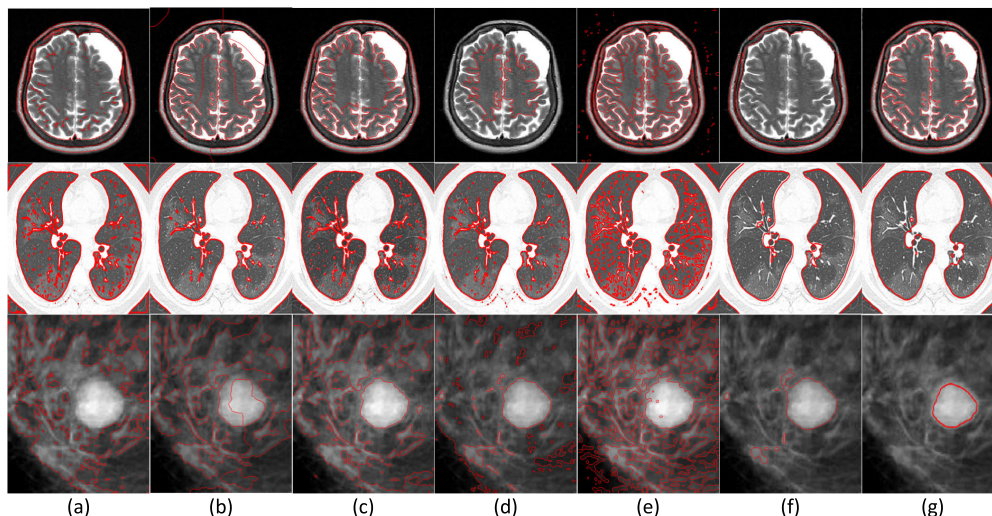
Segmentation and corresponding comparison of brain MRI (Row 1), COVID-19 patient’s lung CT (Row 2), and mammogram (Row 3). (a) CV, (b) LBF (c) VLSBCS, (d) LSACM, (e) LGFI, (f) McGKFCM, and (g) Proposed SalCor.
